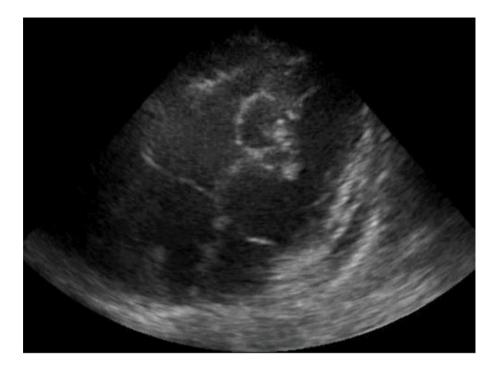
Apical four-chamber view echocardiograph showed a (\rightarrow) heterogeneous, cystic mass in inferior part of interventricular septum.
